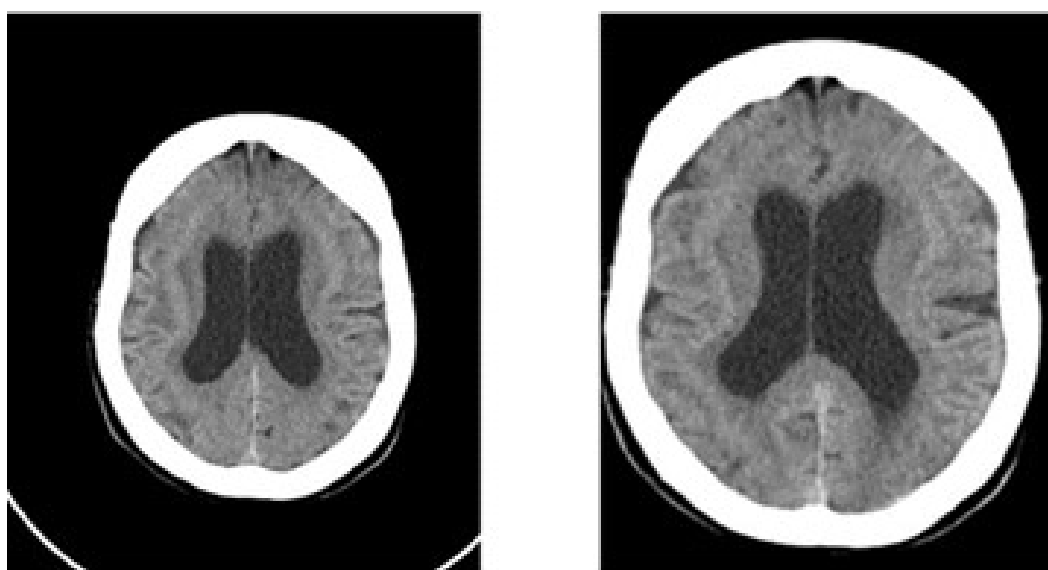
CT Scan Brain showing pachygyria and subcortical band heterotopia
